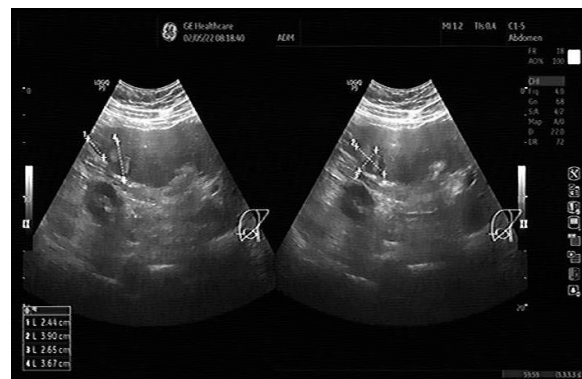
Abdominal ultrasound discovered in segment VI hyperechoic nodular mass with hypoechoic halo, 2.4 cm diameter.
